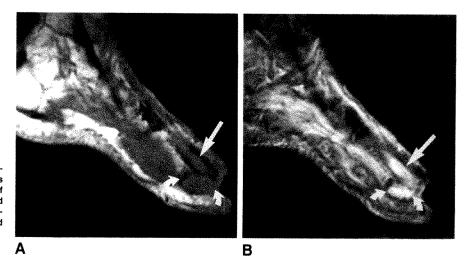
Recurrent osteomyelitis and abscesses in 46-year-old man. Osteomyelitis (straight arrow) and abscess (curved arrows) of metatarsal are readily shown on T1-weighted (683/20) (A) and T2-weighted (2016/100) (B) images. Abscess is better shown on T2-weighted image.
